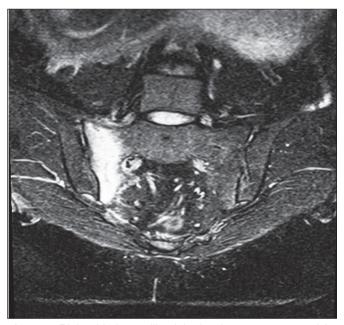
Right-sided sacroiliac joint involvement on coronal fat supression MRI scan (patient no 9).
